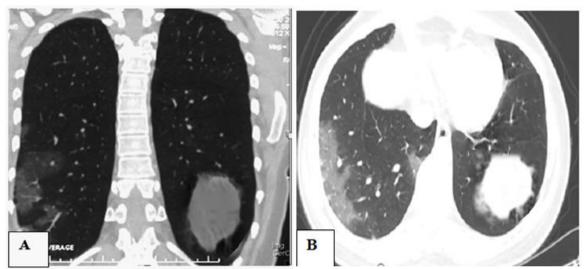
57-years old male patient, with a history of cough and chest pain, referred for CT guided biopsy from the ill-defined pulmonary mass lesion at left lower lobe. (A) and (B) axial and coronal CT chest imaging respectively shows unilateral right sided sub-pleural pulmonary consolidations and ground-glass opacities (CORADS 4)
